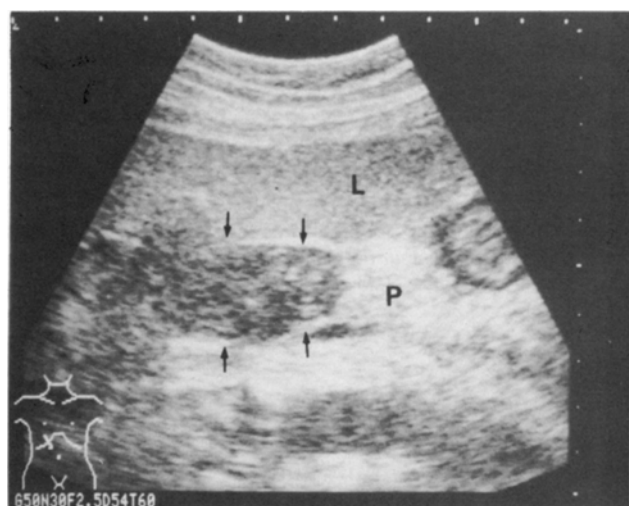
Abdominal ultrasonography demonstrated a slightly hypoechoic mass with clear margin attached to the pancreas (arrows). The internal echo was solid and relatively homogenous. (L: liver, P: pancreas)
